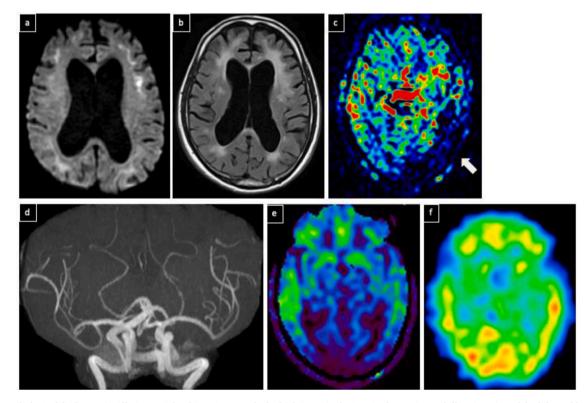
Neuroradiological findings. a) Diffusion-weighted imaging reveals the high intensity legions in the corticomedullary junction of the bilateral hemispheres. b) Fluid-attenuated inversion recovery imaging reveals diffuse high-intensity signal of white matter. c) Arterial spin labeling at the onset shows hypoperfusion in the left hemisphere (arrow). d) Magnetic resonance angiography reveals no significant intracranial arterial occlusive lesions. e) Arterial spin labeling and f) N-isopropyl-p-[¹²³I] iodoamphetamine single-photon emission computed tomography at six days after the admission reveals no apparent hemodynamic changes.
